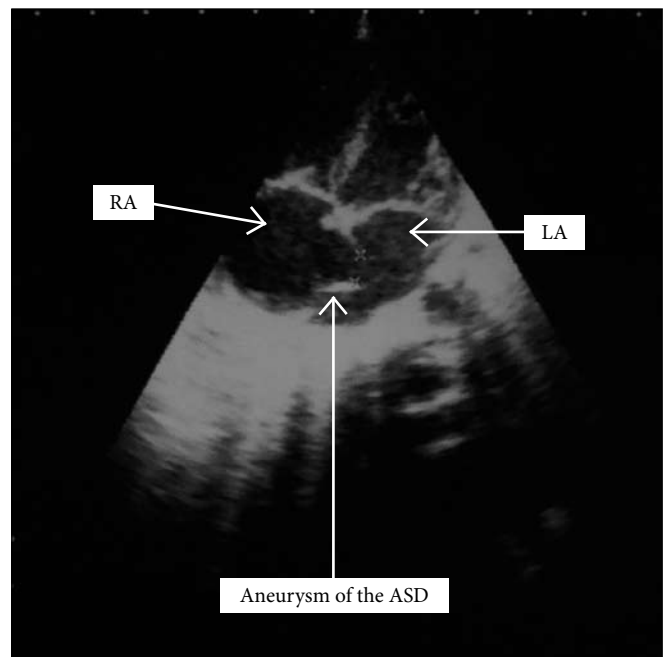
Four-chamber cardiac ultrasound demonstrates enlargement of the RA with aneurysm of the ASD. Doppler studies (not shown) showed right to left shunting of blood.
